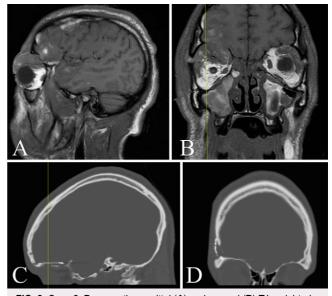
Case 2. Preoperative sagittal (A) and coronal (B) T1-weighted MRI demonstrating a right supraorbital encephalocele. Postoperative sagittal (C) and coronal (D) CT demonstrating the right reconstructed orbit.
